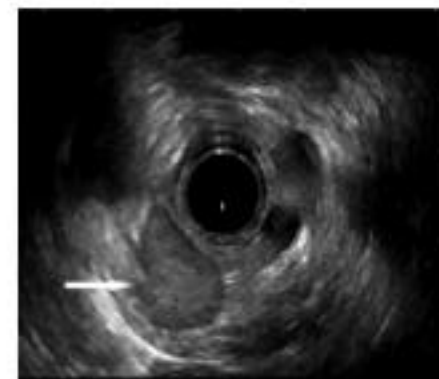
Endoscopic ultrasonography image of the parathyroid adenoma, showing a well-defined hypoechoic, solid lesion
